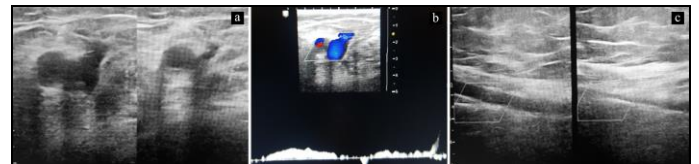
Doppler study showed normal spontaneous unidirectional flow (4a) with phasic variation in the right common femoral vein (4b) and unidirectional flow in popliteal vein (4c) with no thrombus.
